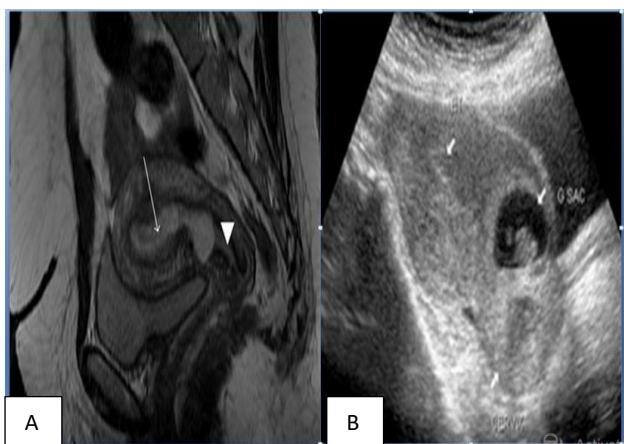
(A and B): Imaging of the patient; left picture depicting MRI T2 weighted image; right picture showing sagittal view of transabdominal depicting the gestational sac implanted at the lower pole of the uterus adjacent to the cervix (arrow), with Bladder being anterior to the scar on the uterus.
